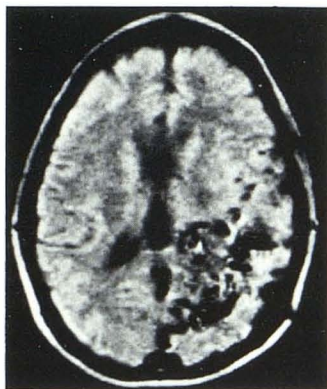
Hemorrhagic infarct. CT scans 2 (A) and 8 (B) weeks after stroke in elderly man reveal focal hemorrhage with peripheral edema followed by apparent resolution with only minimal residual edema in left temporal lobe. C, SE NMR image at comparable level depicts oval high-intensity focus and peripheral less intense foci. D, Calculated T_1 image indicates markedly shortened T_1 within lesion suggesting hemorrhage. E, 9 weeks after stroke. Hemorrhagic component still seen on NMR image (cf. B).
